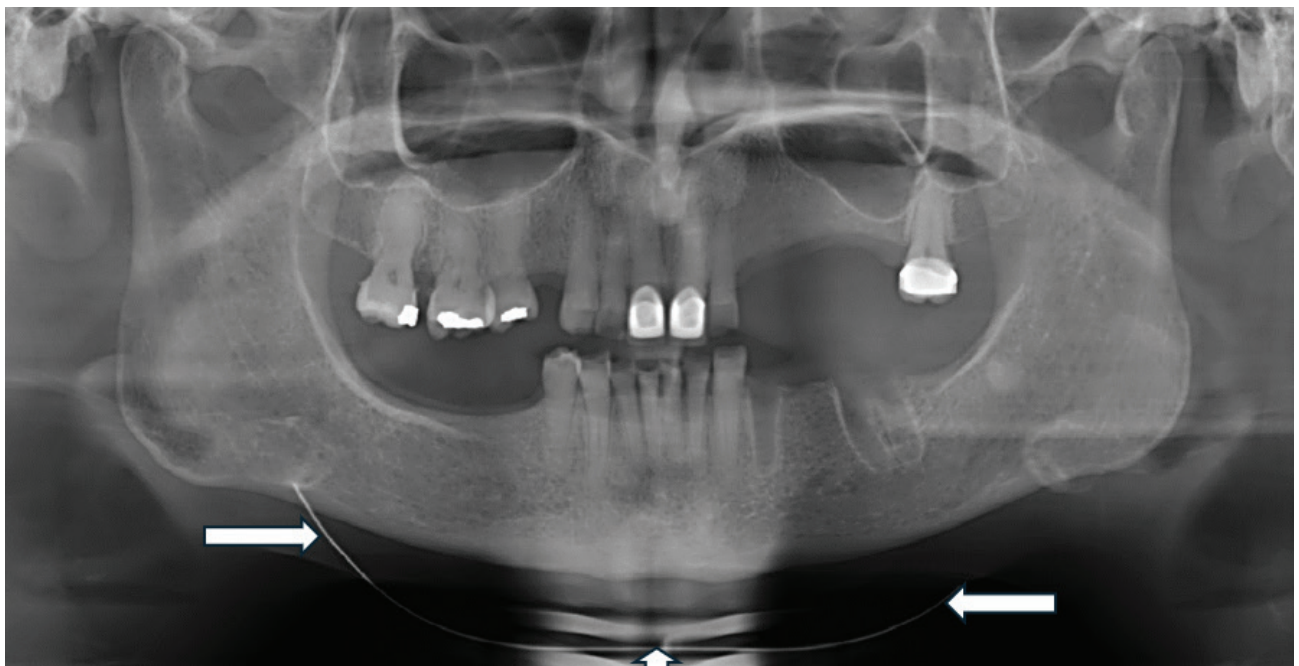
A panoramic radiograph taken of a patient wearing a face mask positioned below the mandible.
